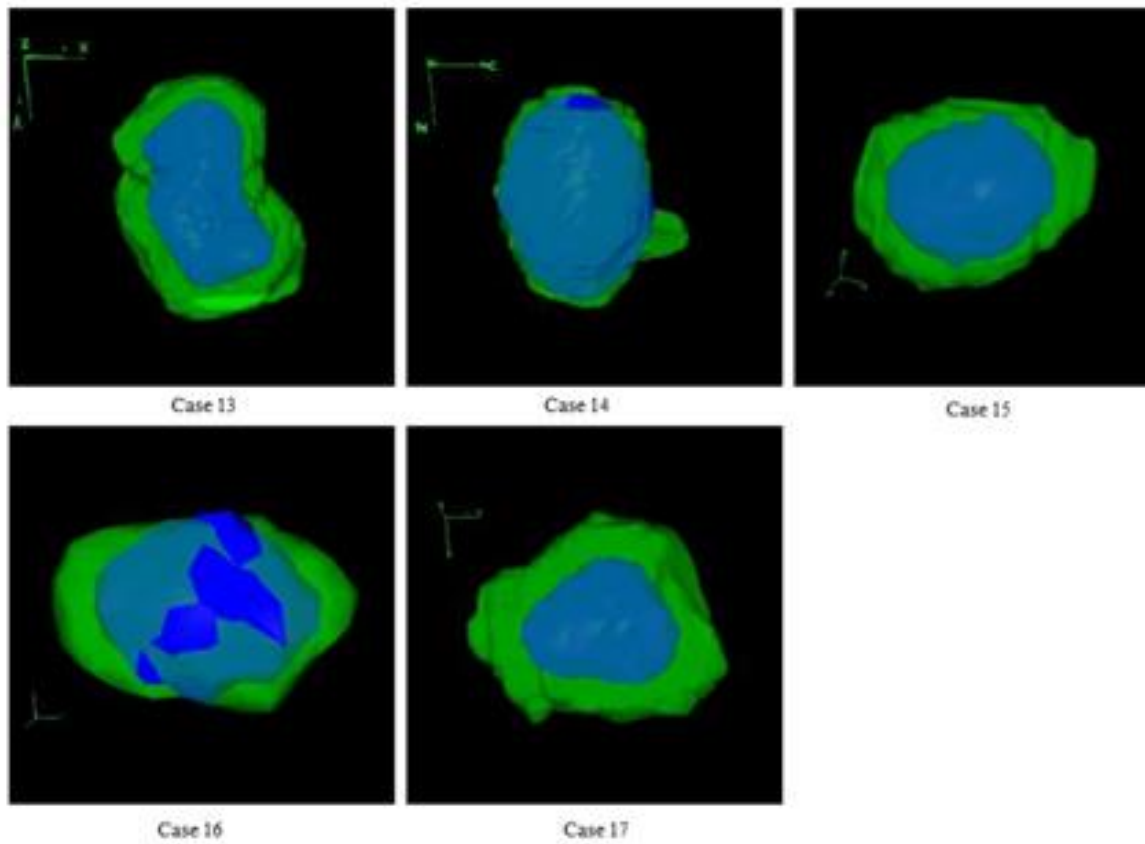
Apposition of the initial (green) and the final (blue) virtual tumours that have been spatiotemporally initialized based on MRI image datasets of 17 clinical tumours collected at two time instants before the start of chemotherapy and after the completion of the treatment.
